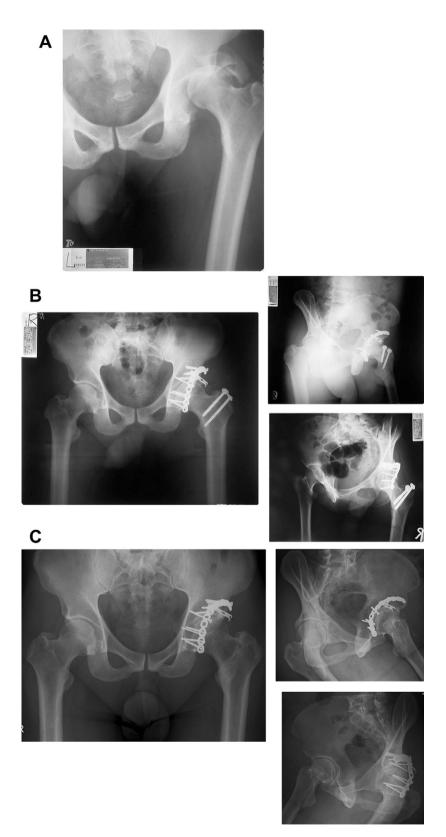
(A) Anteroposterior radiographs of a 48-year-old man who had a comminuted posterior wall fracture-dislocation of the left acetabulum. He sustained an ipsilateral sciatic nerve injury and presented with drop foot. (B) Anteroposterior and 45° oblique radiographs made after ORIF, performed with the Kocher–Langenbeck approach with transtrochanteric osteotomy. Decompression and inspection of the sciatic nerve was performed to check the integrity of the nerve on the involved segment. Marginal impaction of the cartilage was reduced with a bone graft from the femoral osteotomic site and was fixed with a hook plate. The reduction was graded as anatomic. (C) Anteroposterior and 45° oblique radiographs were graded as good because of a slight marginal osteophyte. The clinical result was also graded as good because the injured deep peroneal nerve was only partially recovered. ORIF = open reduction and internal fixation.
